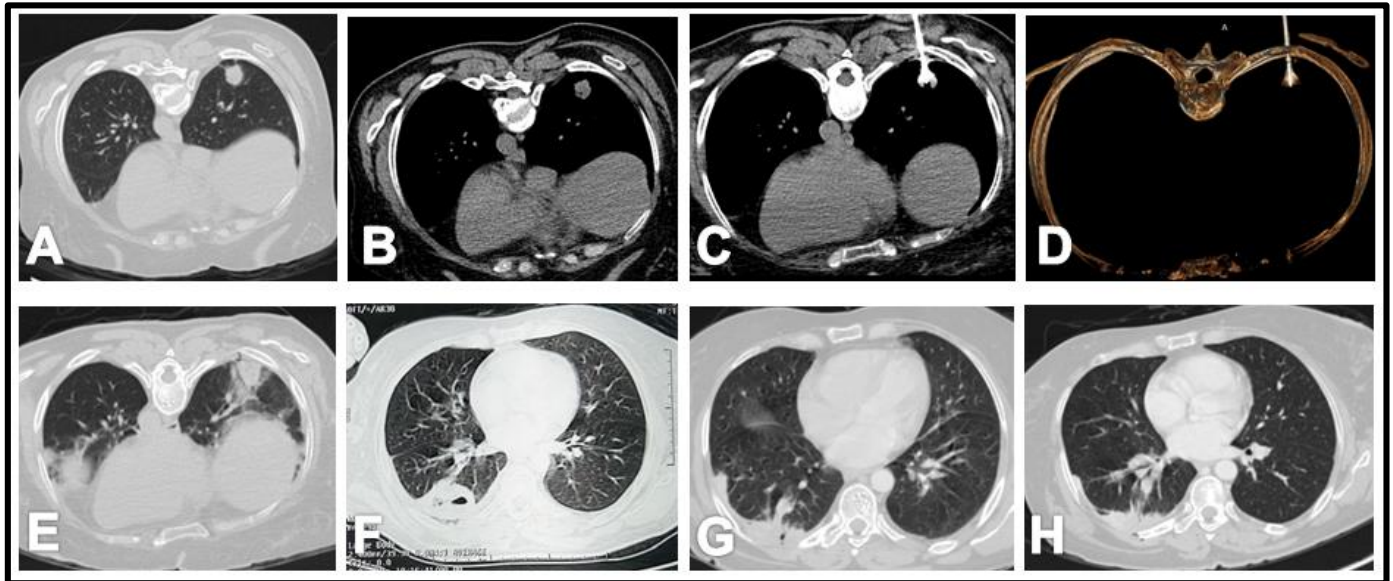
A 51-years-old female had a nodule at the right lower lung lobe, 12 months after whipple operation for pancreatic head cancer. [A]&[B] axial CT cuts, lung and mediastinal window [prone] revealed 18mm round nodule at the right lower lung lobe. [C] reconstructed axial CT cuts &[D] 3D image at prone position revealed MWA antenna at the center of the nodule. [E] Immediately post-ablation, evidence of GGO all around the nodule. [F] 1 month after ablation, evidence of cavitation surrounded with consolidation. [G] 3 months after ablation, loss of cavitation with replacing atelectasis. [H] 6 months' post-ablation, the atelectasis shrank with no evidence of lesions.
